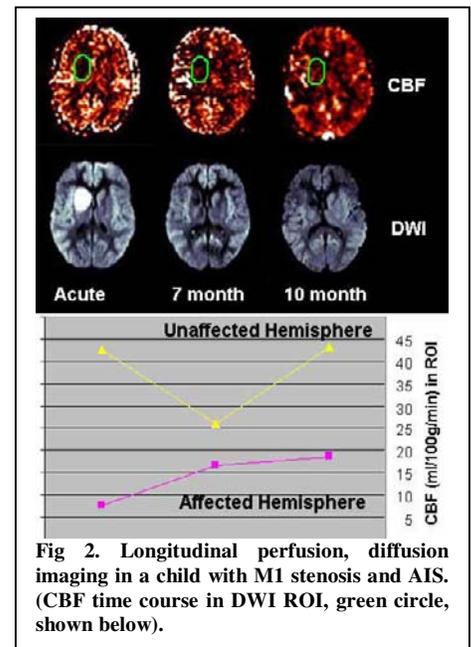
Longitudinal perfusion, diffusion imaging in a child with M1 stenosis and AIS. (CBF time course in DWI ROI, green circle, shown below).
